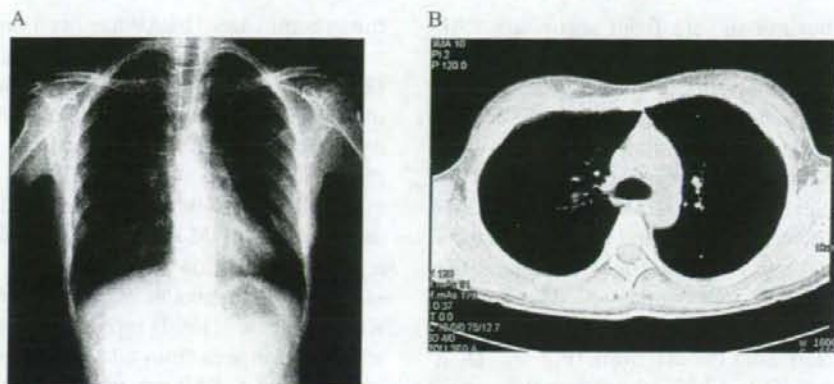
Radiographic appearance 3 years after the diagnosis (April 25, 2005). Diffuse infiltrative shadows on chest radiogram which were seen on August 5, 2002 had disappeared (A). The opacification with a patchy distribution on chest CT also resolved (B).
